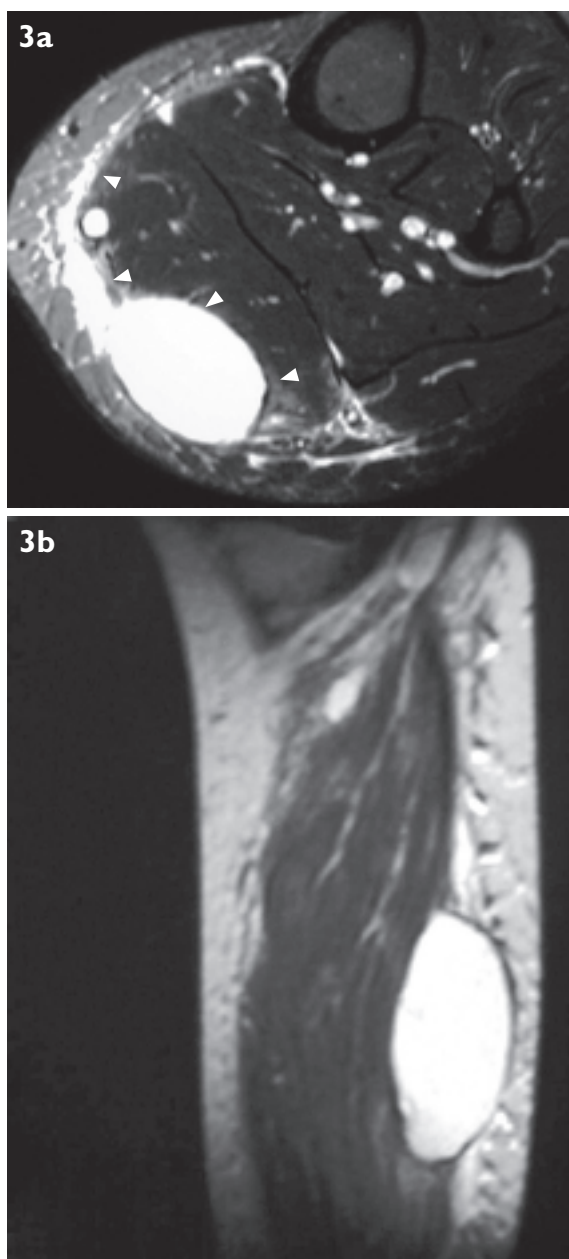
Dissecting popliteal cyst. (a) Axial T2-weighted MR image taken at the level of the upper tibia shows fluid (arrowheads) dissecting between the gastrocnemius muscle and the subcutaneous fat layer of the posterior leg, compatible with a ruptured cyst. (b) Far-sagittal T2-weighted MR image of the upper calf shows the lower extent of the dissecting popliteal cyst.
